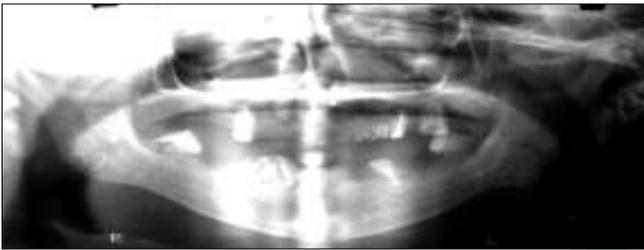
Pre rehabilitation orthopantomograph
